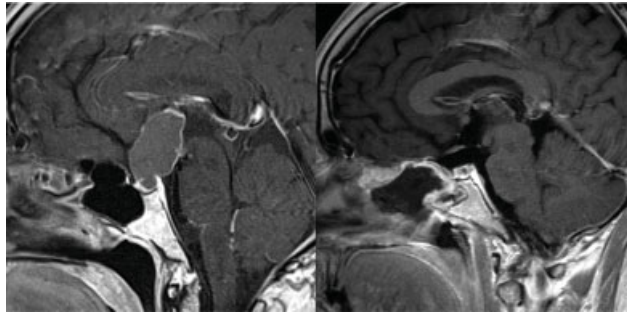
Preop and postop sagittal MRI imaging of a craniopharyngioma resected using the endoscopic endonasal trans-sphenoidal approach.
